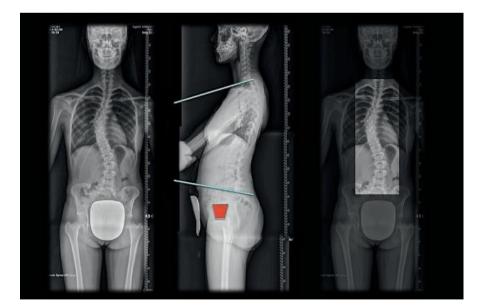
Image of the entire spinal column of a patient with idiopathic scoliosis. As can be seen the head and parts of the legs are on the x-ray which is not necessary at all. On the side view (middle picture) there is no shelter applied. On the right picture one can see the region of interest (ROI) allowing to diagnose the patient well and to measure the Cobb angle. Exposure to radiation drastically can be reduced by limiting the field to the ROI.
